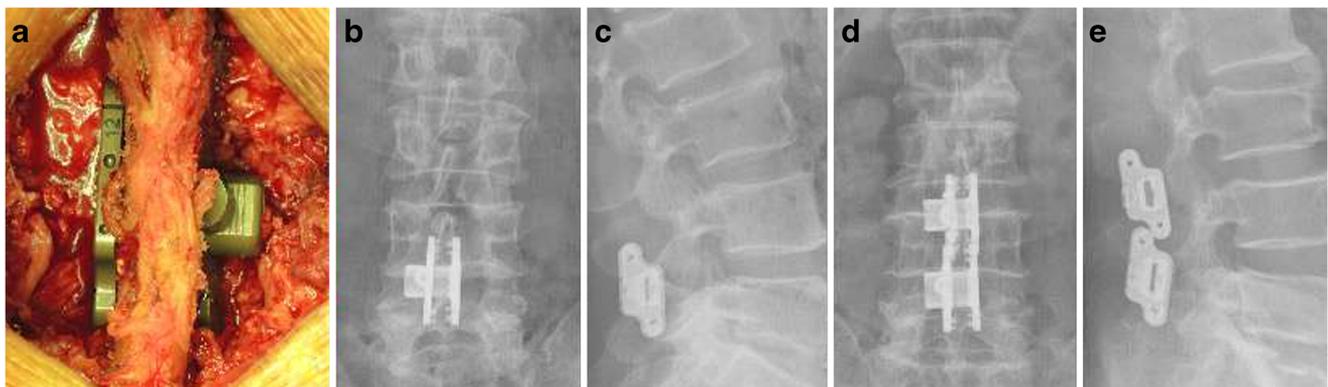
a The image of a fixed spine at operation. b, c The post-operative anteroposterior and lateral X-ray of single-level implantation at L4–5. d, e The post-operative anteroposterior and lateral X-ray of implantation at L3–4 and L4–5
